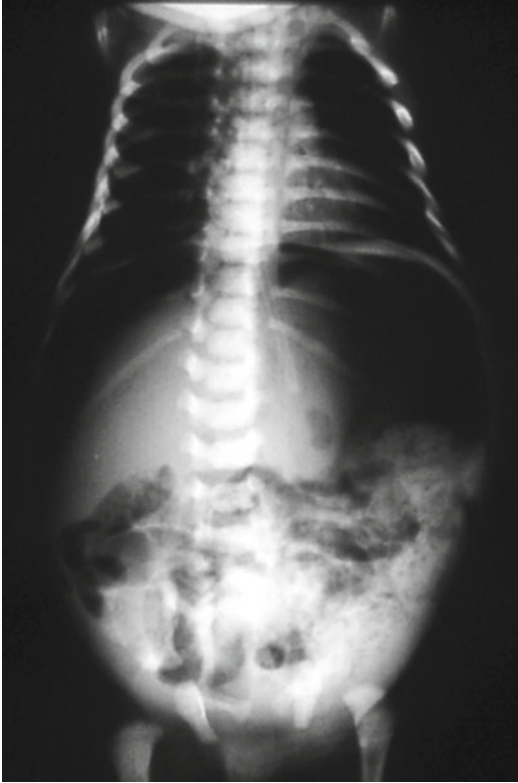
Abdominal plain film in newborn with NEC: massive pneumoperitoneum in this picture is possible to visualize the continuous diaphragm sign
